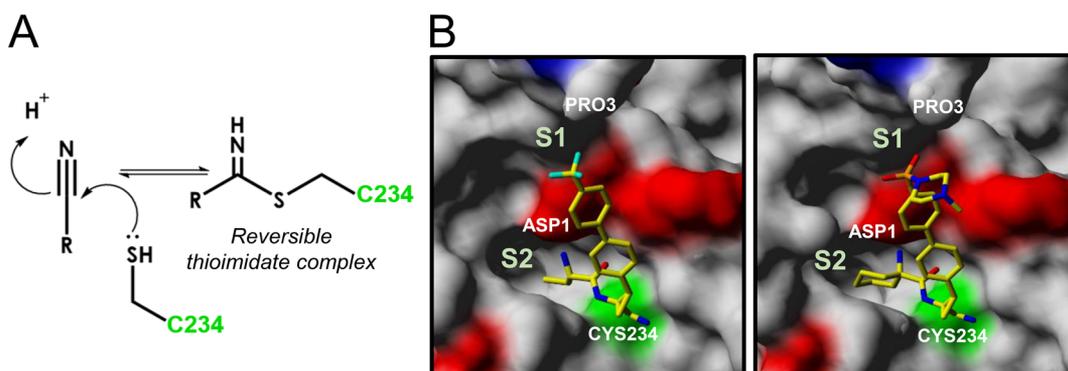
X-ray structures of two dipeptidyl cyclopropyl nitrile inhibitors of CatC. (A) Formation of a reversible thioimide complex resulting in the reaction of the nitrile function with the active site cysteine 234. (B) Solvent-accessible surfaces of CatC complexed with the inhibitors (1*R*,2*R*)-methyl-(*S*)-2-(*tert*-butyloxycarbonylamino)butanamido)-2-(4'-((4-methylpiperazin-1-yl)sulfonyl)phenyl-4-yl)cyclopropanecarboxylate (PDB code 6IC6³²) or 1-amino-*N*-((1*R*,2*R*)-1-cyano-2-(4'-((4-methylpiperazin-1-yl)sulfonyl)-[1',1'-biphenyl]-4-yl)cyclopropyl)cyclohexane-1-carboxamide (PDB code 6IC7³²). Positive and negative electrostatic potential is represented in blue and red, respectively. The Cys234 is colored in green. The images were created with Yasara (<http://www.yasara.org>).
